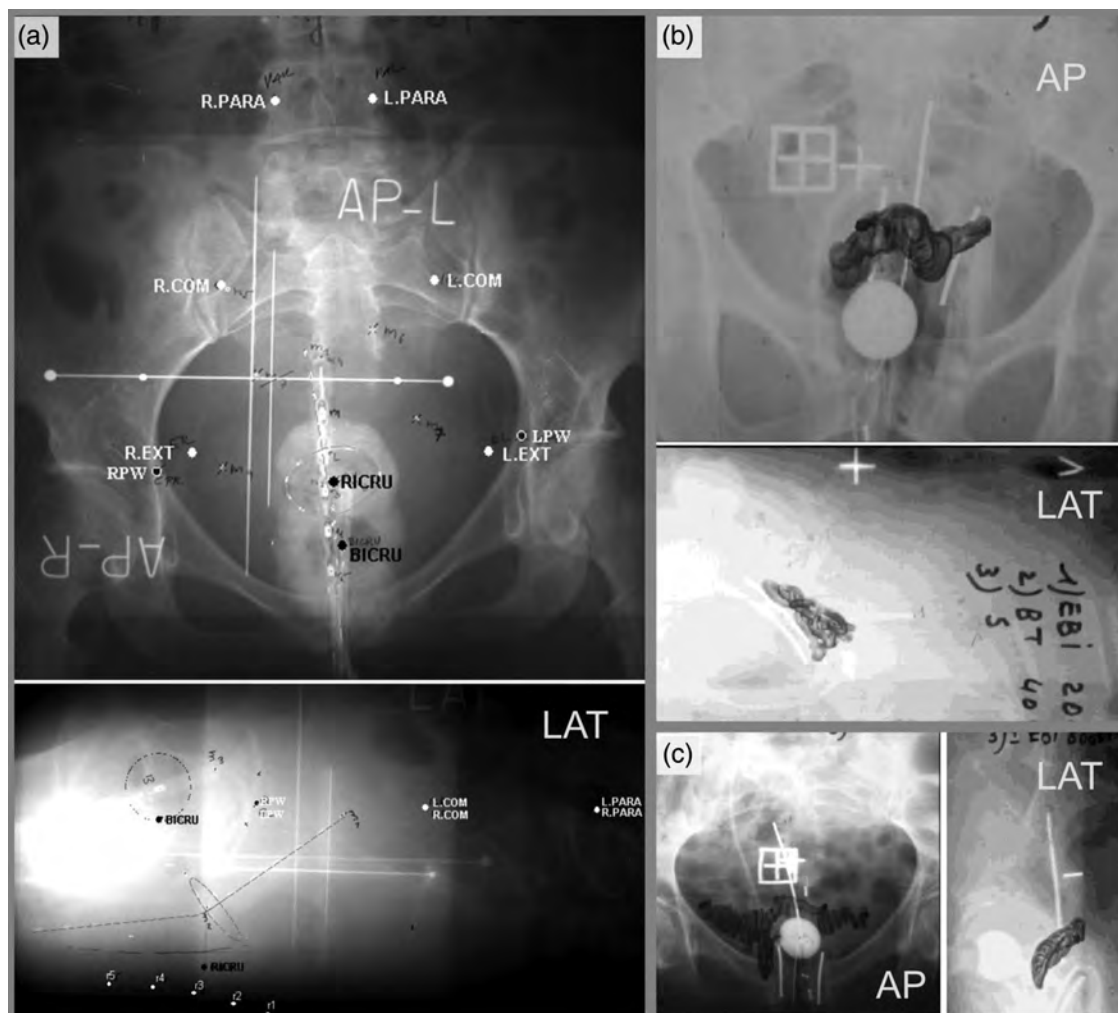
Anteroposterior and lateral radiographs with tandem-ring (a) and tandem-mold (b and c) applicator in place with bladder balloon, vaginal contrast [contrast medium (a); air (b) and (c); rectal probe in the rectum (a)] as basis for radiographic approximation of target dose [from the GEC ESTRO Handbook of Brachytherapy 2002 (Gerbaulet *et al.*, 2002a)]. (a) Bladder (BICRU) and rectum (RICRU) reference points (compare with Figure 10.6), rectal probe points, pelvic wall points, and lymphatic trapezoid (compare with Figures 10.4 and 10.5); (b and c) Delineation of the tumor extension based on gynecologic examination at diagnosis (IIB and IIIB) for radiographic approximation of target dose (see also Section 10.3, Figure 10.3).
